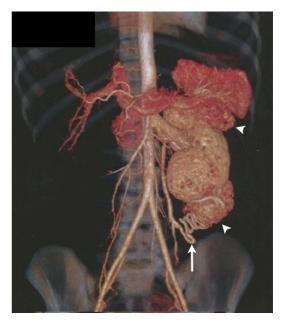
Reconstruction from the computed tomography executed for planning of endovascular treatment. The arrowheads indicate the two larger tumors, located at the upper and lower poles of the kidney; the arrow indicates the arterial pedicle associated with vascularization of the lower pole tumor. Note the absence of the right kidney due to the previous nephrectomy.
